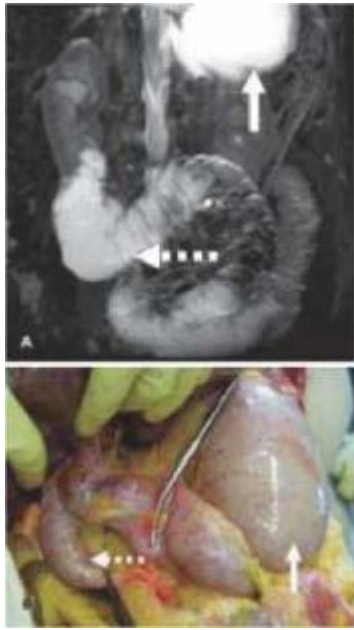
MRI and autopsy of individual deceased by drowning. (a) Coronal MRI slice; (b) autopsy image. Source: Taken from Dirnhofer *et al.*
